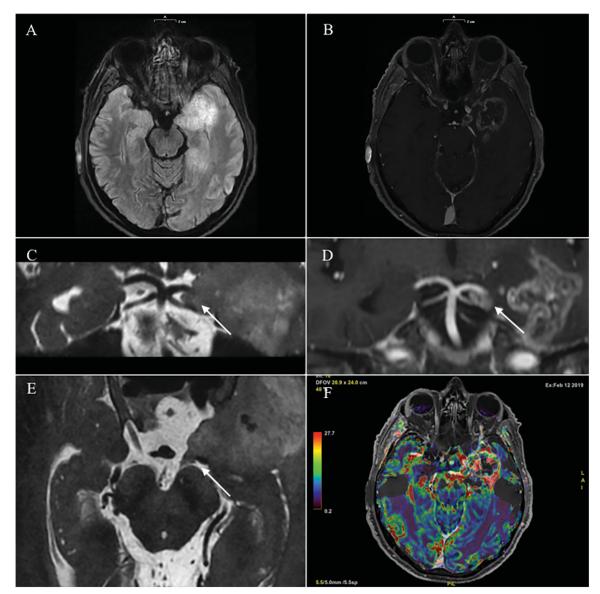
Axial T2-FLAIR and T1-weighted MR images with gadolinium (A and B) showing an enhancing cystic-necrotic lesion in the left temporal lobe extended to the oculomotor cistern. The midbrain appeared not involved. On coronal and axial CISS sequences the oculomotor nerve (white arrow) appeared markedly enlarged (C, E) and characterized by a visible contrast enhancement (D). DSC MRI perfusion study showed high rCBV values within the tumor and within the left oculomotor nerve, without midbrain involvement (F).
